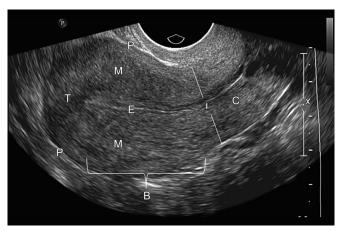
Transvaginal ultrasound of the uterus. Note the uterine fundus (F), uterine body—upper 2/3 of the uterus (B), isthmus—junction between the body of the uterus and cervix (I) and cervix (C) lower 1/3 of the uterus
